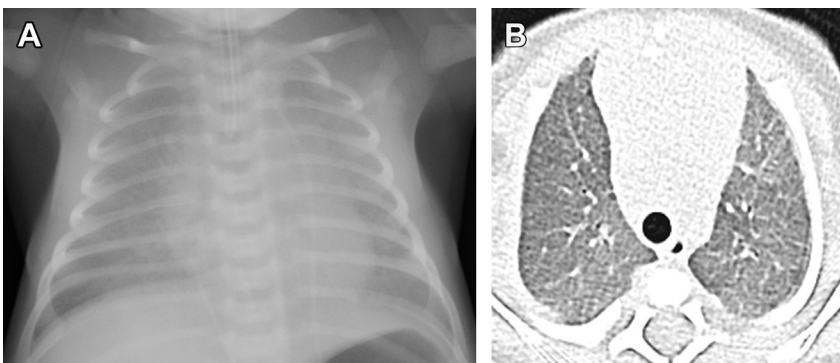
A 26-day-old girl born at full term with congenital surfactant protein B deficiency. (A) Chest radiograph demonstrates diffuse bilateral hazy pulmonary opacities. (B) Axial lung window CT image shows diffuse ground glass opacity throughout bilateral lungs.
